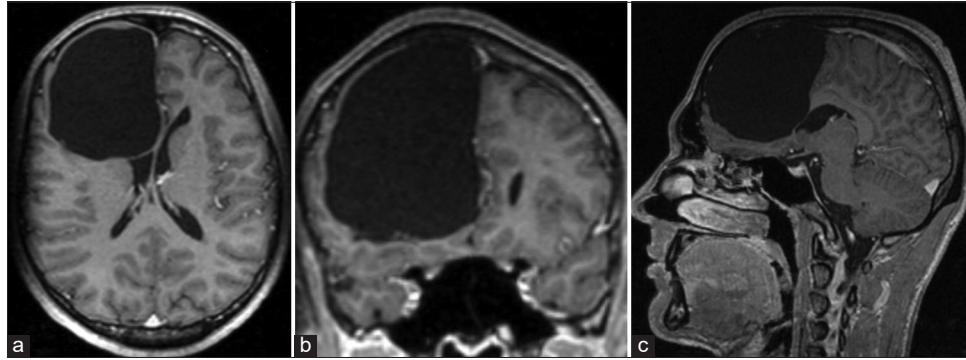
Axial (a), coronal (b), and sagittal (c) T1 gadolinium-enhanced brain MRI of arachnoid cyst (7 × 8 × 7 cm).
